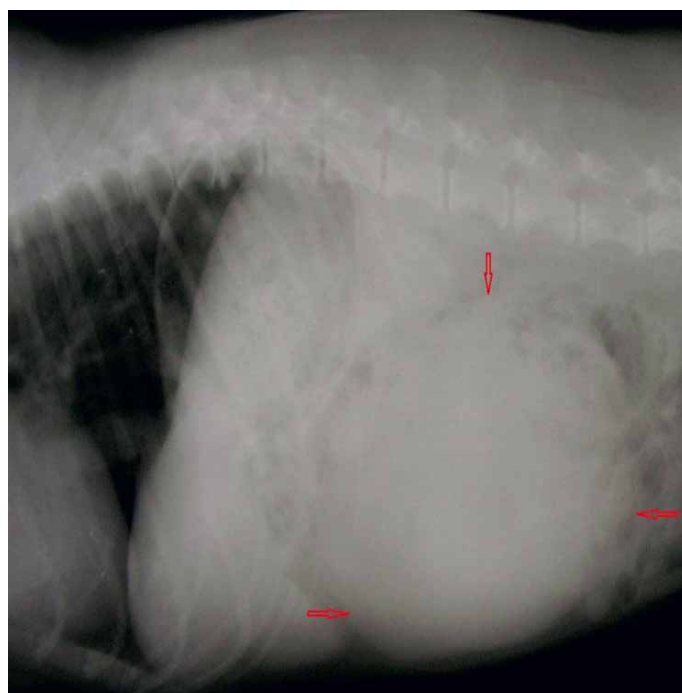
Radiography of the abdomen reveals a large mass
